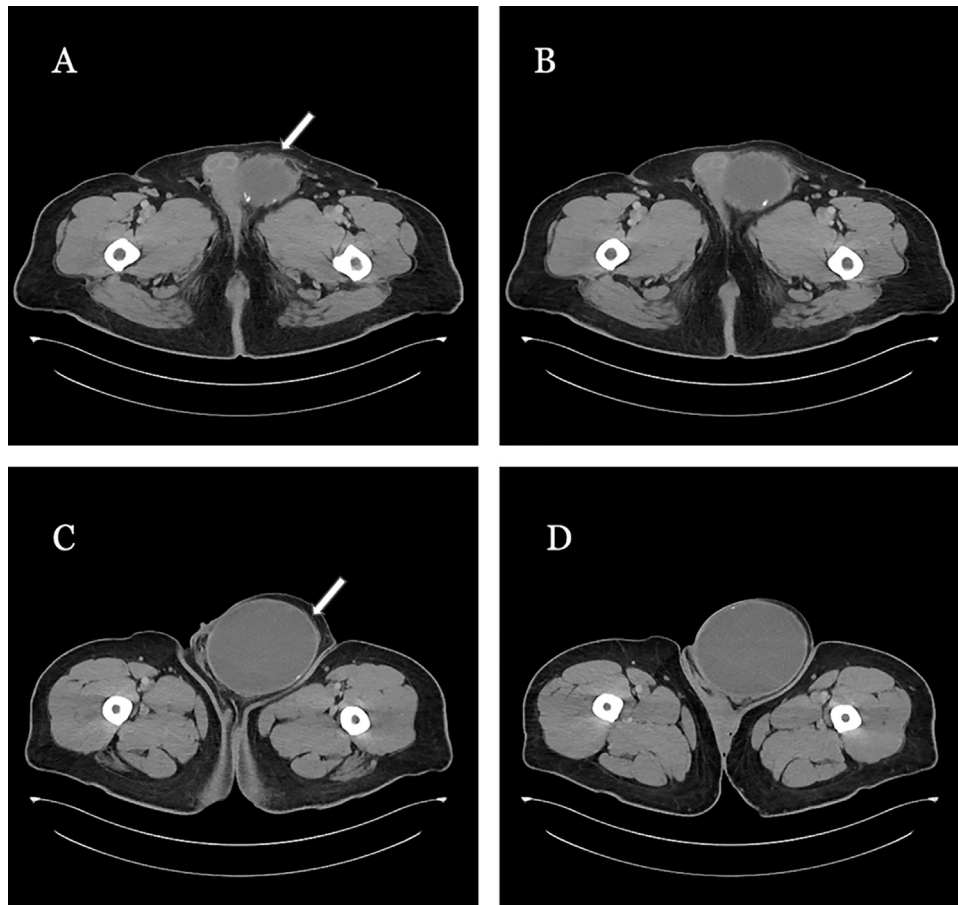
Computed tomography demonstrating an inguinal canal lesion. There was evidence of a prior repair (panel A; arrow). There is a well-circumscribed 12.0 cm fluid collection. A fibrous capsule vs. hernia sac is demonstrated (panel C; arrow).
